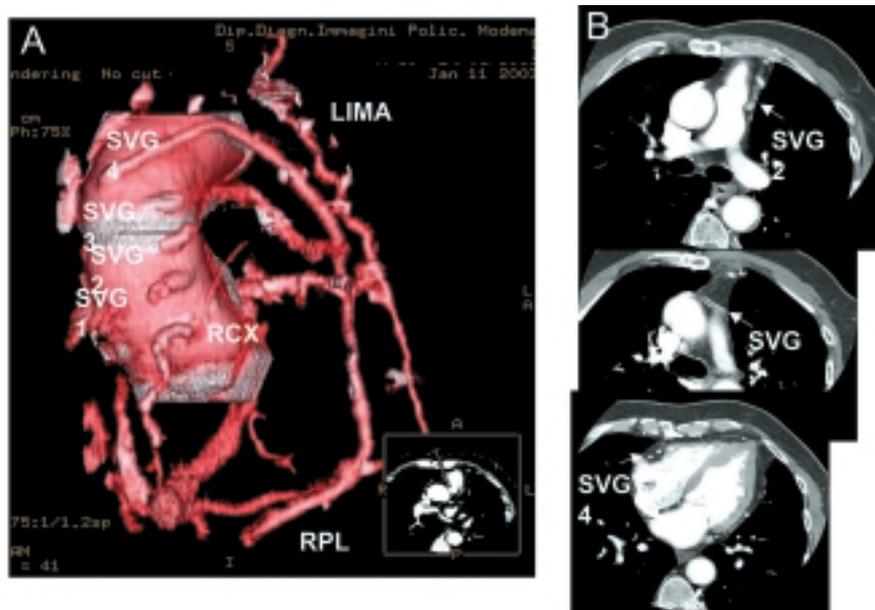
Right anterior oblique volume rendering projection after subtraction of the cardiac chambers (A) and axial spiral multislice computed tomography angiography images at three different levels of the aortic arch (B). These images confirm the patency of the arterial bypass (left internal mammary artery-LIMA) and of the more cranial saphenous vein graft (SVG4); the lack of enhancement of the lumen of the remaining three venous grafts (SVG1, SVG2, SVG3) confirms that they are occluded at their origin. RCX = right coronary artery; RPL = postero-lateral branch.
